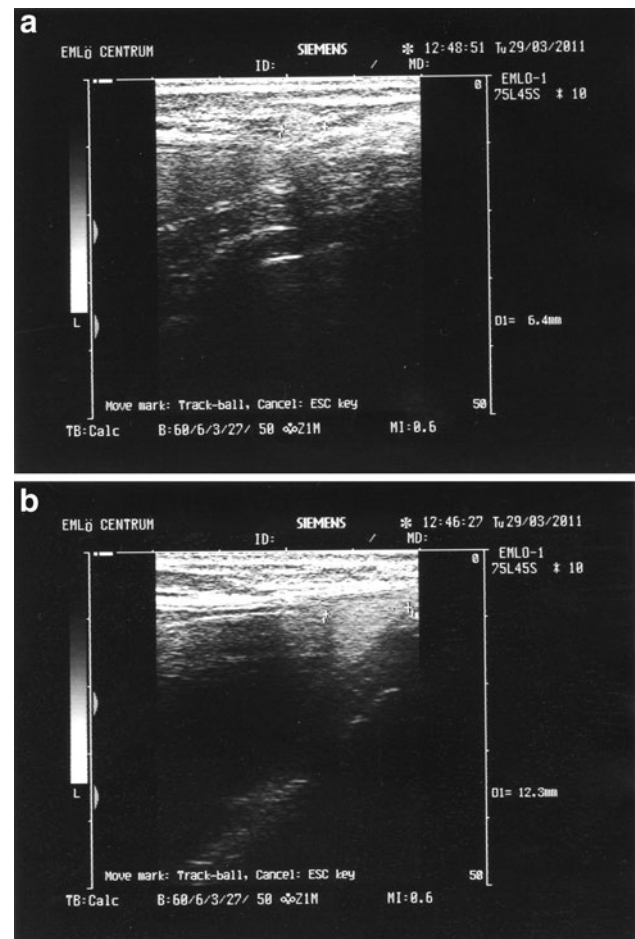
Ultrasonographic evidence of silicone traces inside one or more lymph nodes in one of the axillae. a Patient 14 (M.N.). Silicone in the lymph node of the *left axilla*. b Patient 8 (M.J.). Silicone in the lymph node of the *right axilla*
